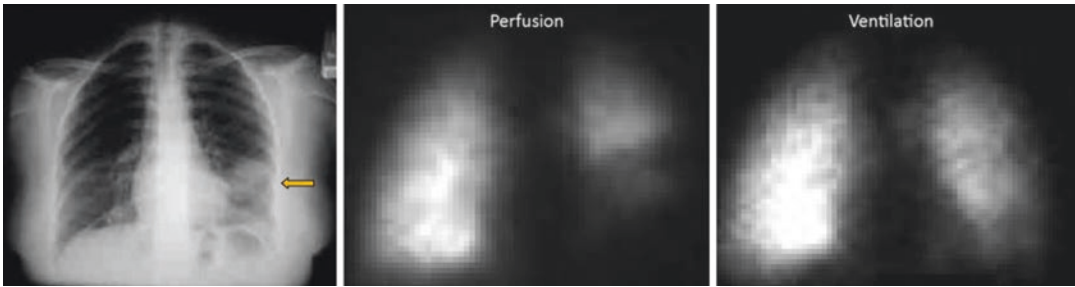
Chest X-ray of a patient referred to rule out pulmonary embolism with a density in the left lower lobe (arrow) matching the perfusion defect on ^{99m}Tc -MAA
